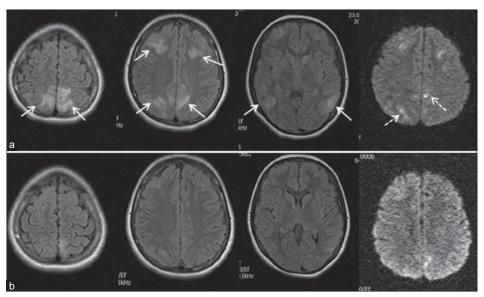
(a) Brain magnetic resonance imaging showing bilateral frontal, parietal, and temporal cortical vasogenic edema (arrows) and diffusion restricted sites (intermittent arrows). (b) Second magnetic resonance imaging (performed 12 days later) showing nearly totally recovery of lesions
